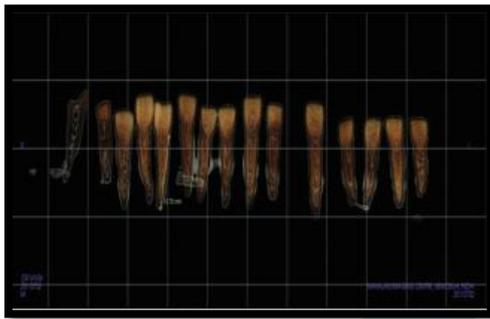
The CBCT image showing the measure dimensions
